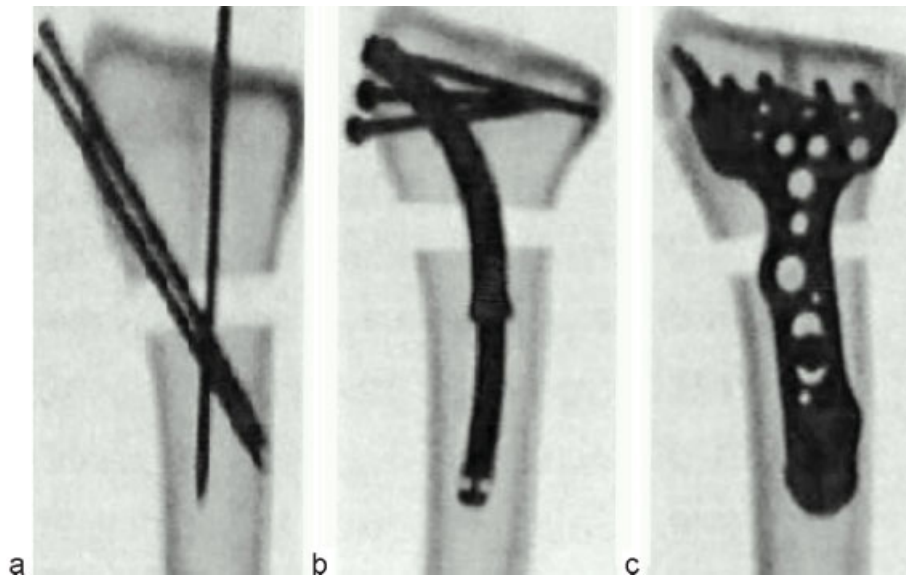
(a–c) Radiographic confirmation of implant positioning.
